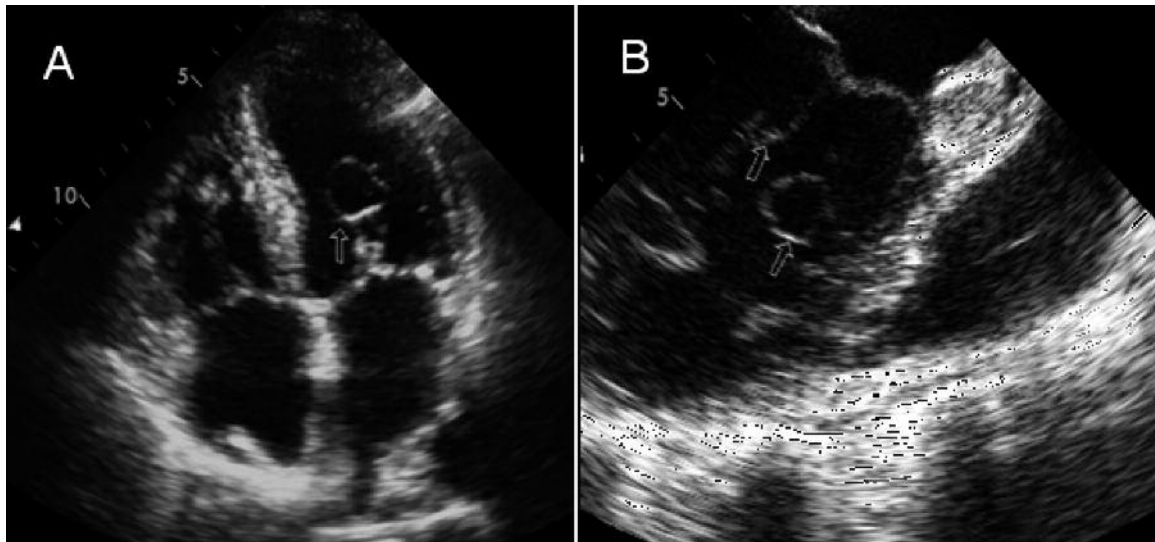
A, Echocardiographic view of the twenty five years old patient on apical four chamber view. The accessory mitral valve tissue was attached to anterior mitral leaflet. B, Accessory mitral valve tissue in TEE.
